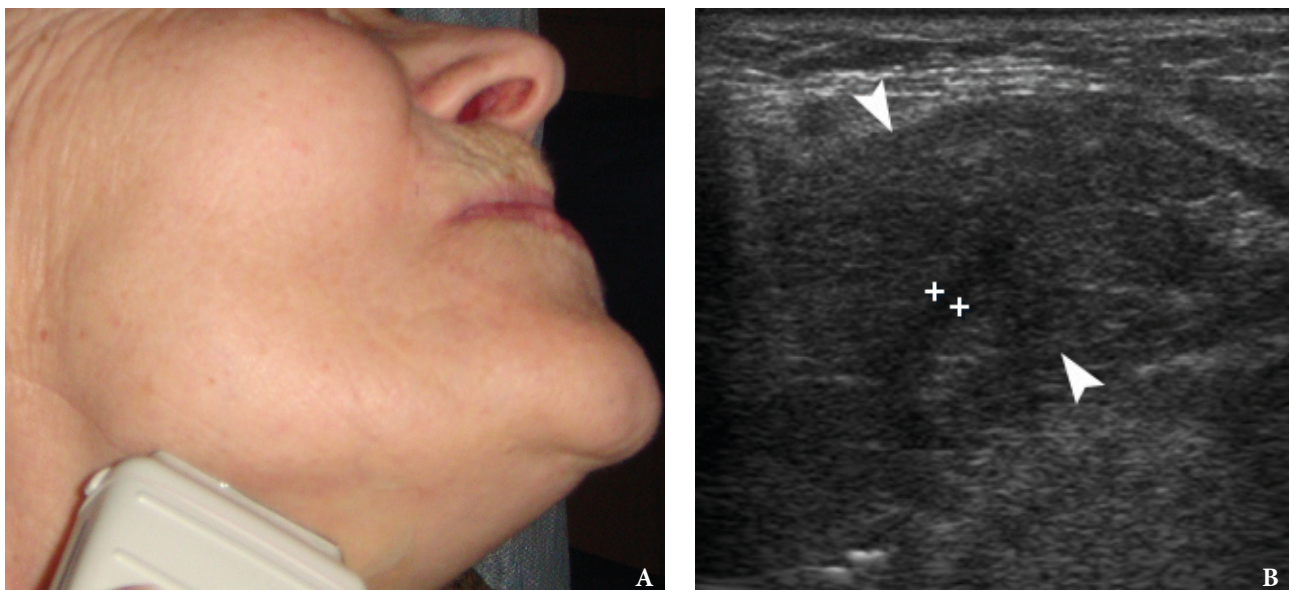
Image A shows position of linear probe. On gray scale sonogram (B) notes dilated intraglandular duct (is indicated by '+' calipers) measured 1.6 mm in the right submandibular gland (*arrowheads*).
